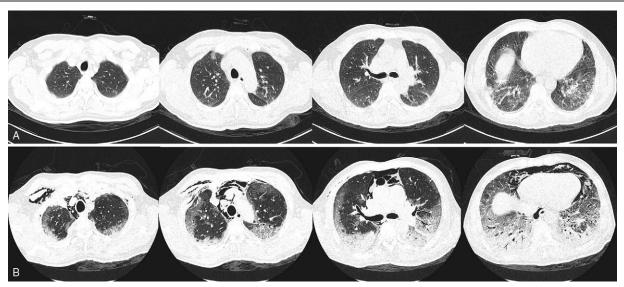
A, Chest HRCT 5 days before admission showing bilateral patchy infiltrations, mainly of the lower lung area, with mild pleural effusion. B, Chest HRCT 6 days after admission showing extensive bilateral ground glass opacities, reticular opacities, consolidation, pneumomediastinum, and subcutaneous emphysema in the right. HRCT = high-resolution computerized tomography.
